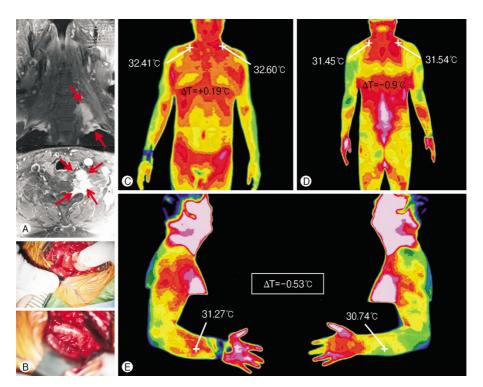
(A) A mass is identified with irregular margin in left C7, 8 nerve roots trough cervical MRI scan with gadolinium enhan- cement. (B) Gross total removal of the mass without injury of normal nerve. (C) Broad distribution of hyperthermal area of the anterior body side, it is not significant sign. (D) Hypothermia of the on posterior body side (ΔT = -0.9°C). (E) Hypothermia of the distal area on the upper extremities according to C7, 8 dermatome (ΔT = -0.53°C).
